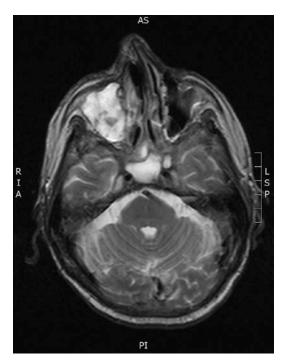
T2-weighted MRI
